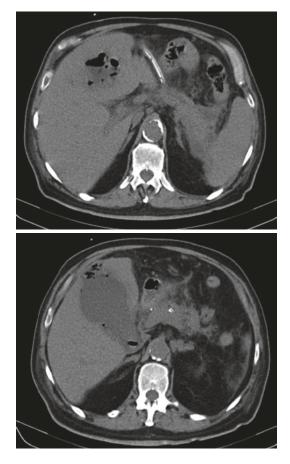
Same patient as in Fig. 3.1: CT at 3 weeks showing gallbladder with significant distension (115/80 mm), with thickened, irregular walls, nonhomogenous mixed fluid, para-fluid and multiple air blob contents, associated with significant densification of the adjacent fat structures, with inflammatory infectious aspect; continuity solution present at the level of the gallbladder fundic area, with intrahepatic penetration in the fourth liver segment, with gaseous, fluid, and parafluid accumulation at this level, approximately 50/45 mm in size axially, without biliary lithiasis—acute acalculous cholecystitis with inhospital onset, in a critically ill patient, with pericholecystic liver abscess
